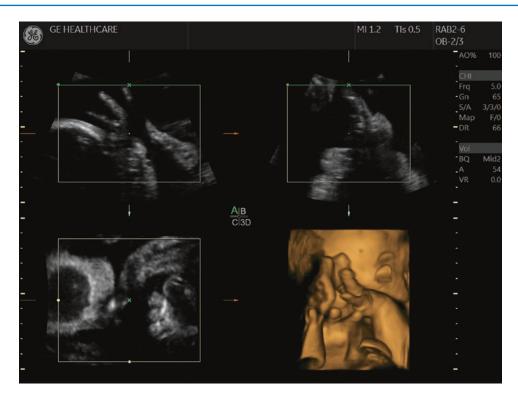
Volumetric ultrasound images of fetus in 3 (Three) views
